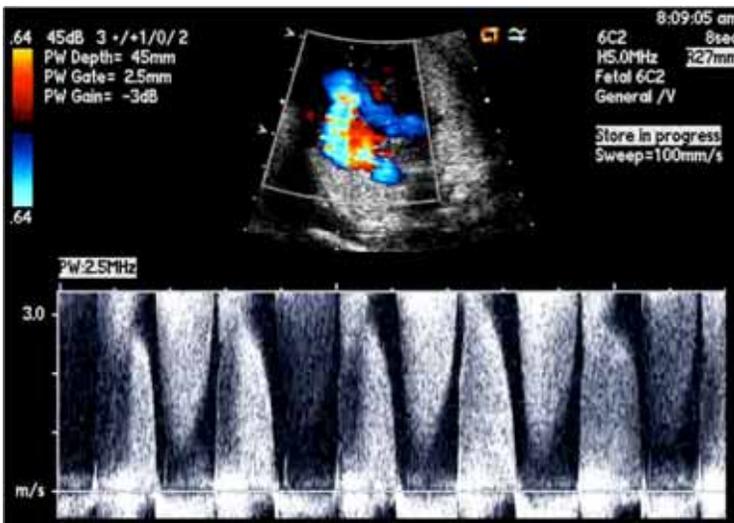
Tetralogy of Fallot with absent pulmonary valve. Note the pulmonary stenosis and pulmonary insufficiency by Doppler interrogation.
